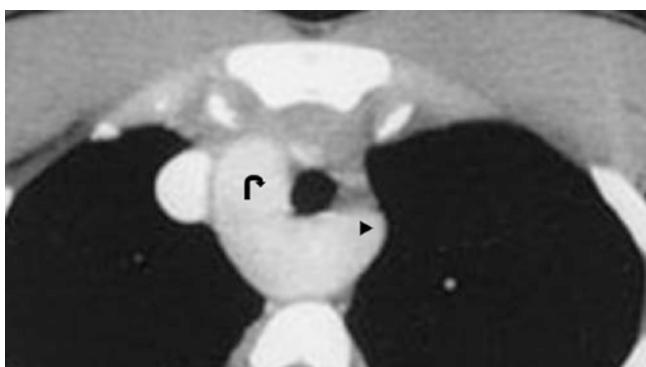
Contrast-enhanced CT scan from a 10-year-old that depicts a right-sided aortic arch (*asterisk*), from which a retroesophageal LSCA (*right-facing arrowhead*) arises. This patient did not have an associated cardiac anomaly. *Aortic Arch* (*curved arrows*); *IA* Innominate Artery (+); *LCCA* Left Common Carotid Artery (○); *LSCLA* Left Subclavian Artery (▶); *RCCA* Right Common Carotid Artery (•); *RSCLA* Right Subclavian Artery (◀)
